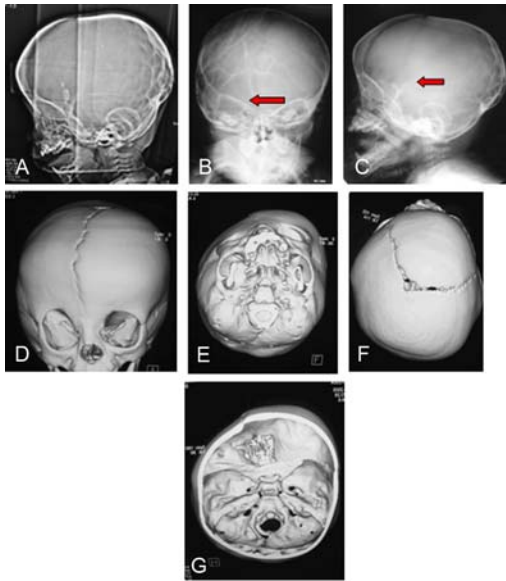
Plain films (A, B, C) and CT scans (D, E, F, G) of a patient with unilateral right coronal synostosis and bilateral lambdoid synostosis
